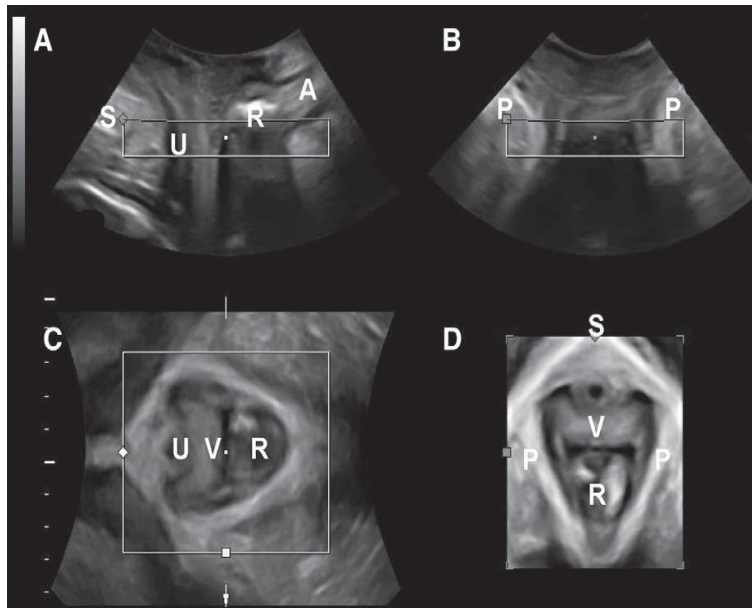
Standard acquisition screen of 3D pelvic floor ultrasound. A - Midsagittal, B - coronal, and C - axial planes and D, rendered axial plane of female pelvic floor. Region of interest is represented in the transparent box [115].
